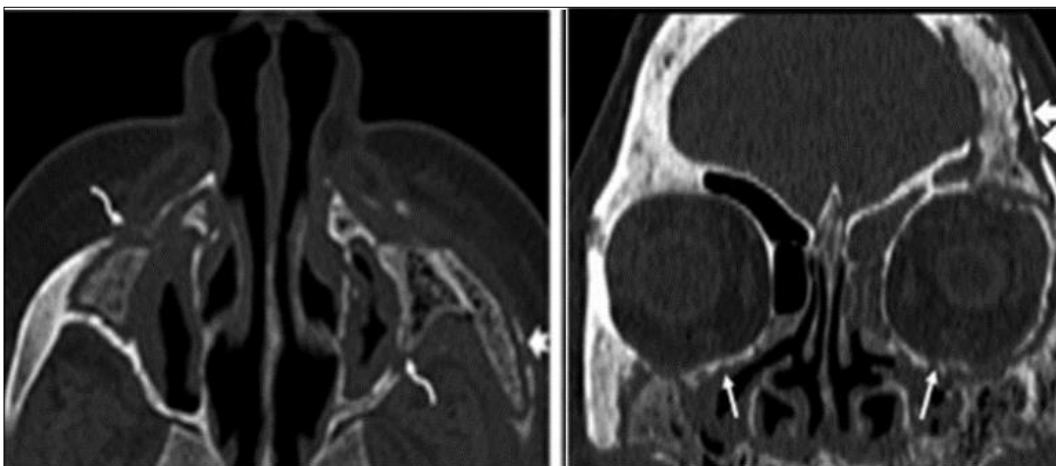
A female aged 50 y with poorly controlled hyperglycaemia and post-COVID-19 infection with 2-weeks duration. Axial and coronal reformatted CT imaging demonstrates bony erosions of the wall of both maxillary sinuses, left zygomatic bone, left frontal bone, floor of bilateral orbits
